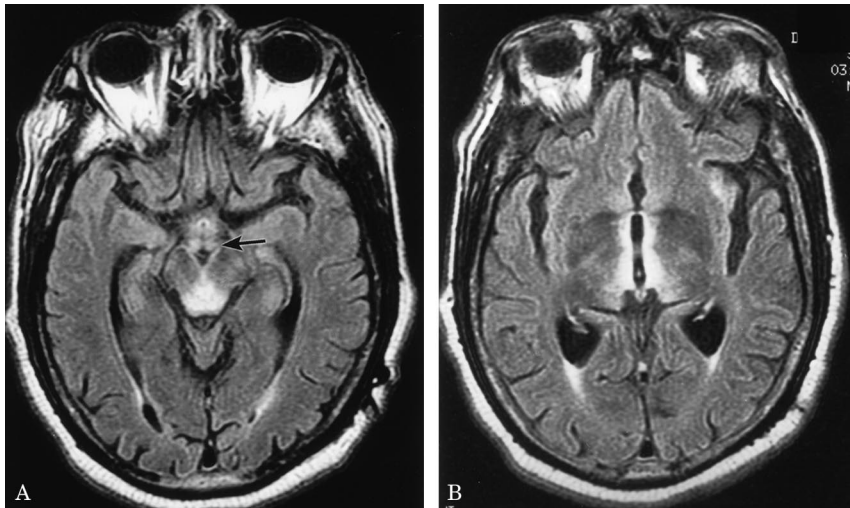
FLAIR brain MR images demonstrated increased signal around the third and fourth ventricles, Sylvian aqueduct, mammillary bodies (indicated by arrow), and tectum. These radiologic findings are typical for Wernicke's encephalopathy, and are believed to reflect regions of cytotoxic edema.²
